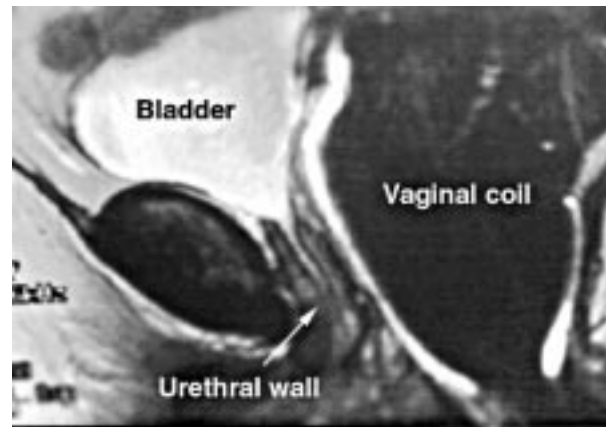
MRI by vaginal coil Sagittal view
